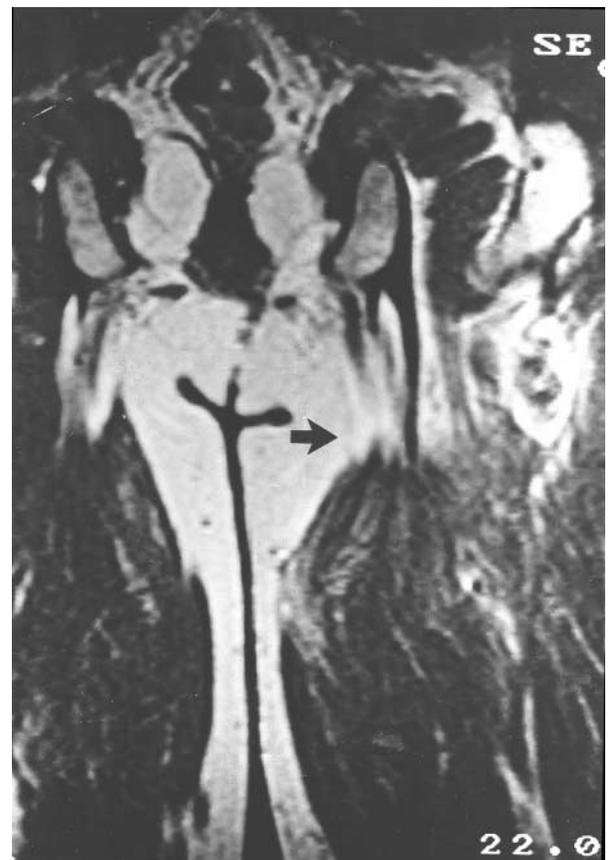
Follow-up coronal T1-weighted MR image (TR, 500 ms; TE, 20 ms) shows atrophy and retraction of semimembranosus and semitendinosus muscles (*arrow*)
